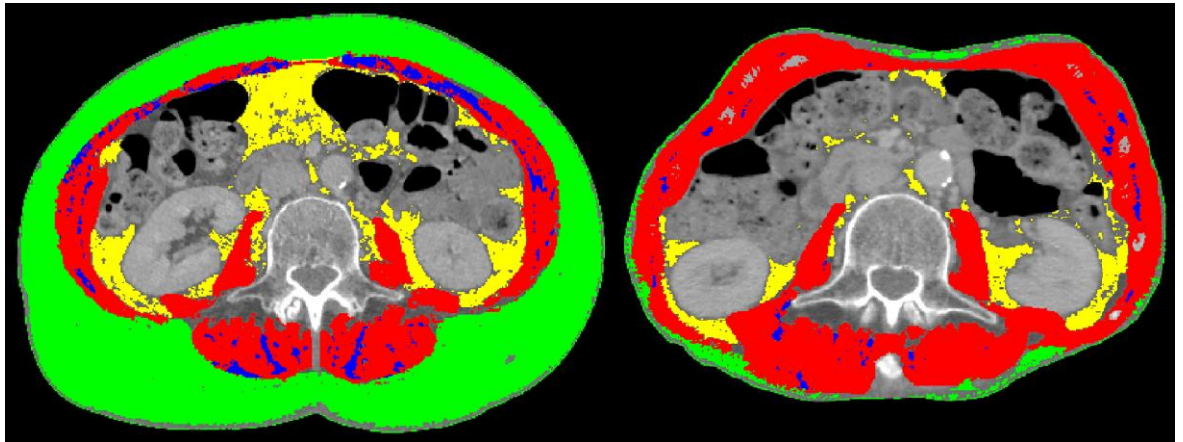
Axial CT scan slices of two patients in the TRACERx study delineated by me demonstrating the differences in adiposity between patients. Subcutaneous (green), visceral (yellow) and intra-muscular (blue) adipose tissue compartments are visible. The red represents skeletal muscle. The image was created on Slice-O-Matic® software v5.0 (TomoVision, Montreal, Canada)
